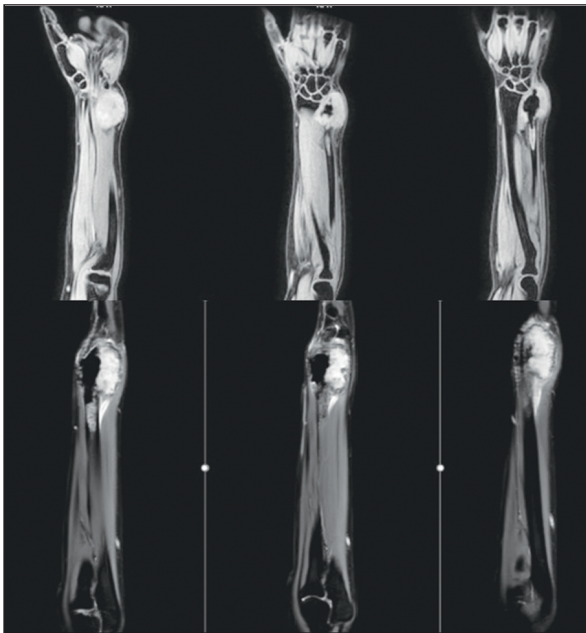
Magnetic resonance imaging scan demonstrations of the giant cell bone tumor in distal ulna after 2 surgeries and denosumab treatment. In the figures, we can see the giant cell bone tumor originating from distal ulna and spreading to the soft tissues around the wrist joint.
